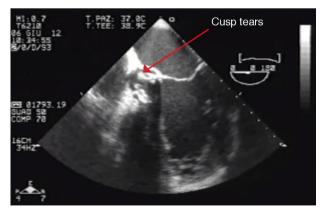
Transesophageal echocardiography, 4-chamber midesophageal view, showing prosthesis degeneration and cusp tears (red arrow).
